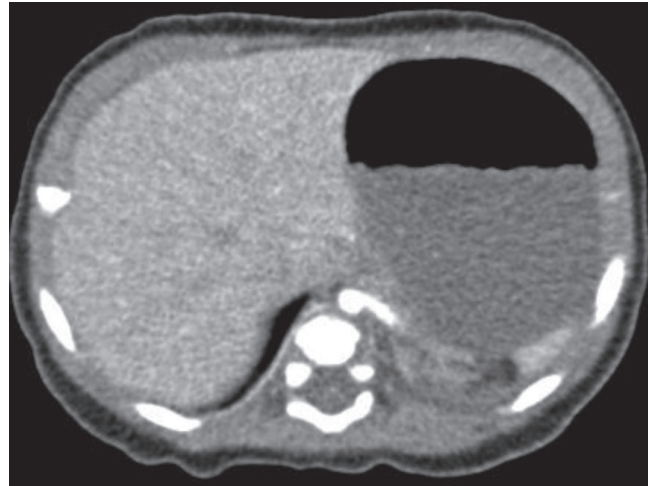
Contrast-enhanced axial CT image demonstrates an anomalous artery arising from the descending aorta and supplying blood to the malformed lung tissue located in the medial left lower lobe.
